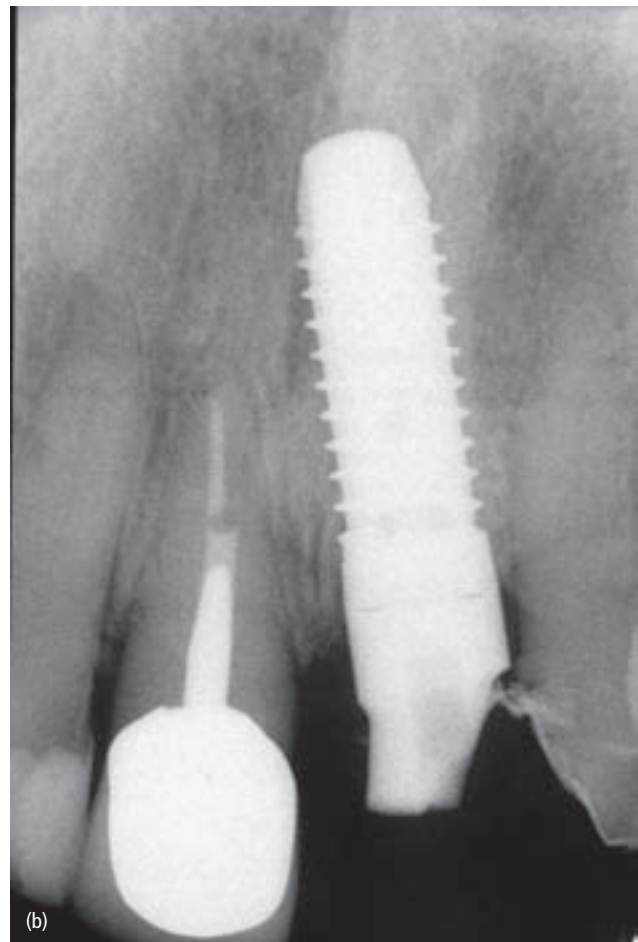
(a) A severe esthetic complication with a recession of the facial mucosa at implant 9, which was placed as an immediate implant after extraction of tooth 9. The harmony of the gingival line is completely disrupted. In addition, both peri-implant papillae are reduced in height. (b) The periapical radiograph shows that the implant was inserted in an apical malposition, roughly 2 mm too deep. In addition, the incorrect axis of the implant resulted in a position too close to the adjacent tooth 10, leading to the complete loss of the papilla.
